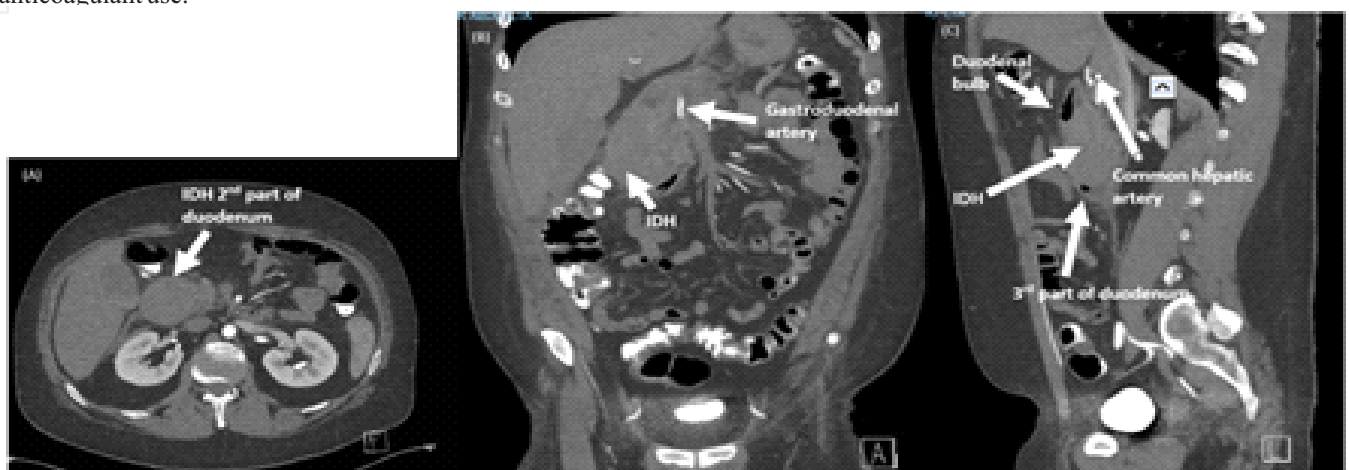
(A) Axial CT abdomen angiography arterial phase demonstrating a 50mm IDH in the 2nd part of the duodenum with no active contrast extravasation. (B) Coronal CT abdomen angiography with a normal calibre gastroduodenal artery and no complicating pseudoaneurysm. (C) Sagittal CT abdomen angiography showing the 1st, 2nd and 3rd part of the duodenum and common hepatic artery.
